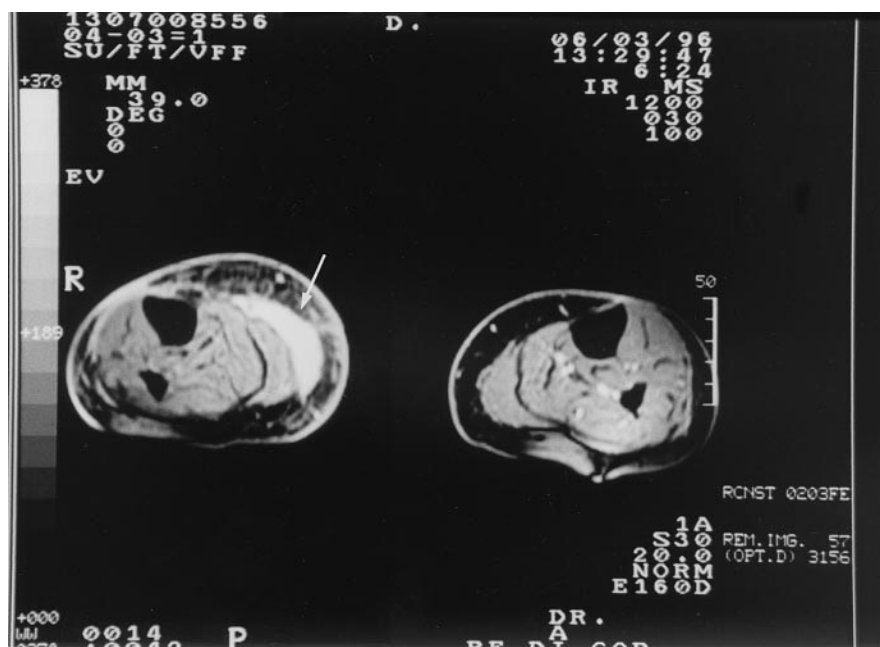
T2-weighted MRI scan: increased density of the lesion in the right internal gastrocnemius, corresponding to focal muscle infarction (arrow) (47).
